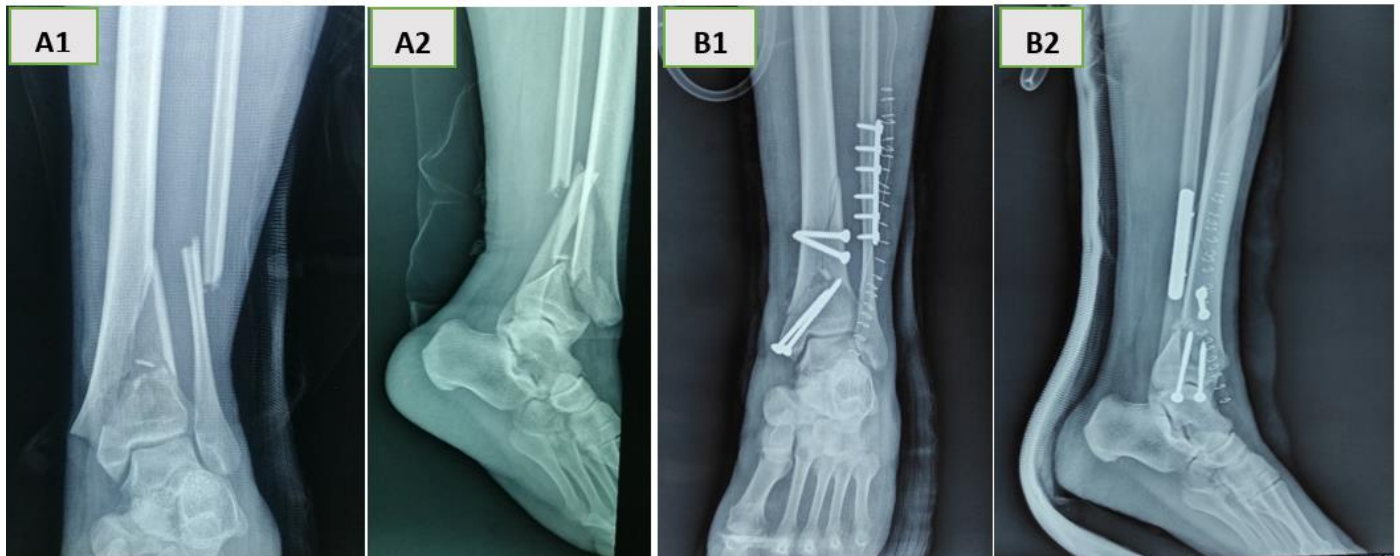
Initial radiograph of a tibial pilon fracture in frontal (A1) and lateral (A2) views, with postoperative radiographic control in frontal (B1) and lateral (B2) views.
